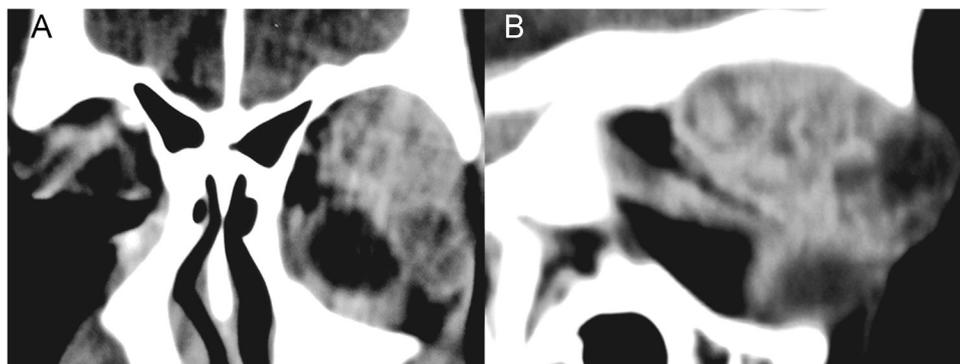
(A) Computed tomography (CT) scan (coronal section) shows a large heterogeneous mass in the left lacrimal gland fossa with multiple cysts within the mass. Globe indentation is also present. (B) CT scan (sagittal section) shows a well-defined, heterogeneously enhancing multicystic mass associated with bony remodeling.
